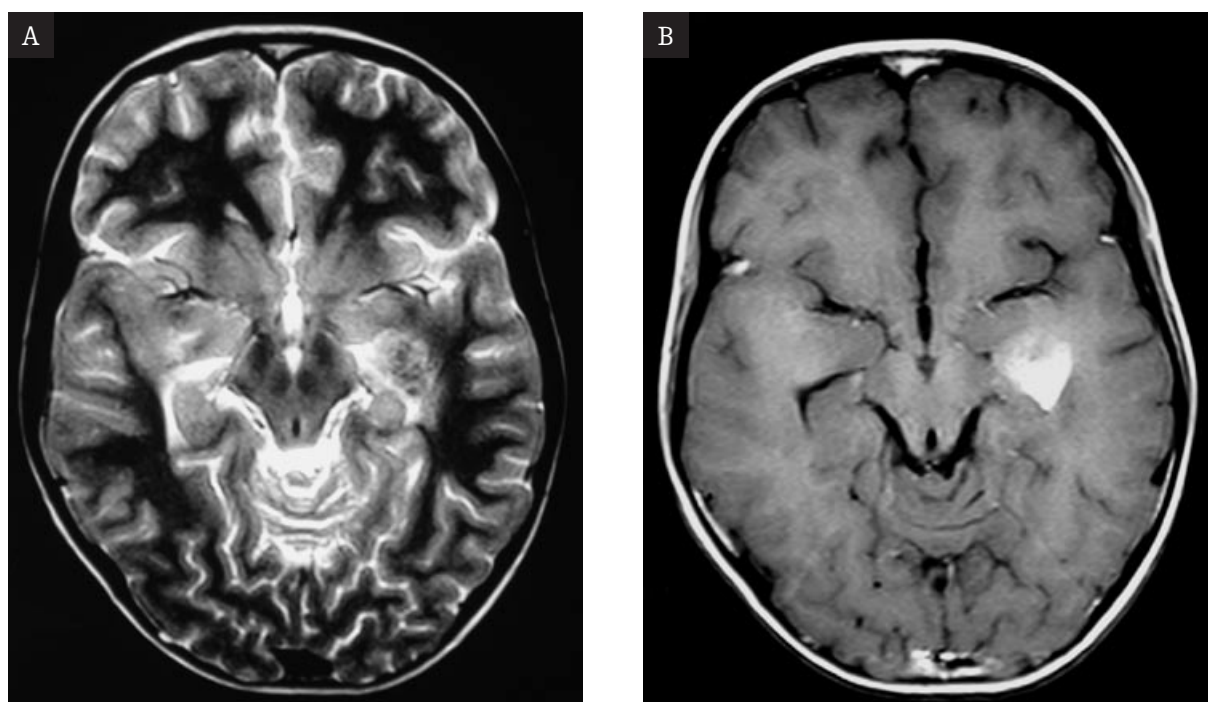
Metastatic lesion in the left temporal lobe of the astrocytoma observed after surgery of the primary tumor. Axial T2-weighted (A) and post-contrast T1-weighted (B) images. Heterogeneous tumor without peripheral edema of the brain tissue.
